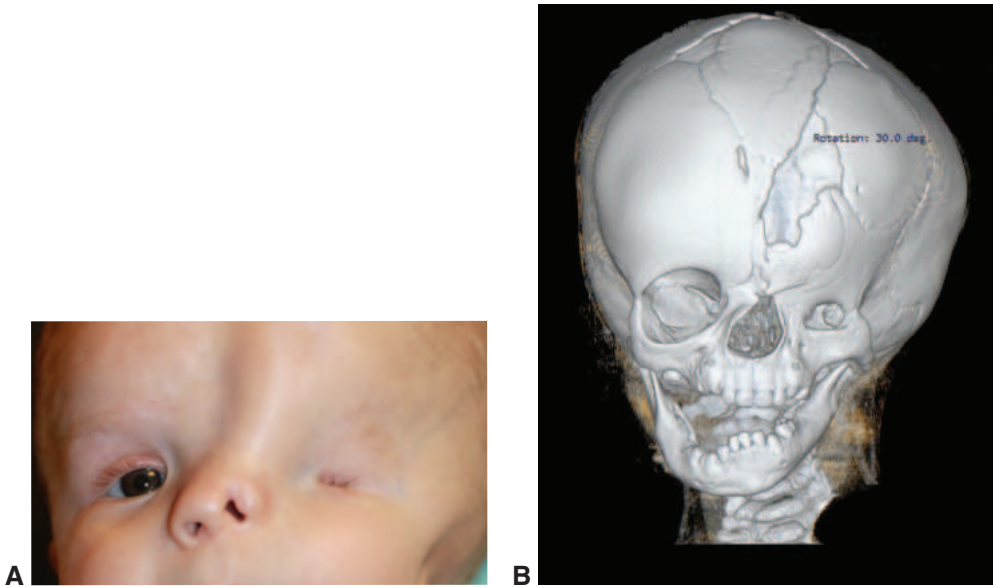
Hemifacial microsomia. A, Clinical photograph demonstrating left-sided hemifacial microsomia. B, Three-dimensional CT reconstruction of same patient. (Courtesy of Jill A. Foster, MD.)
